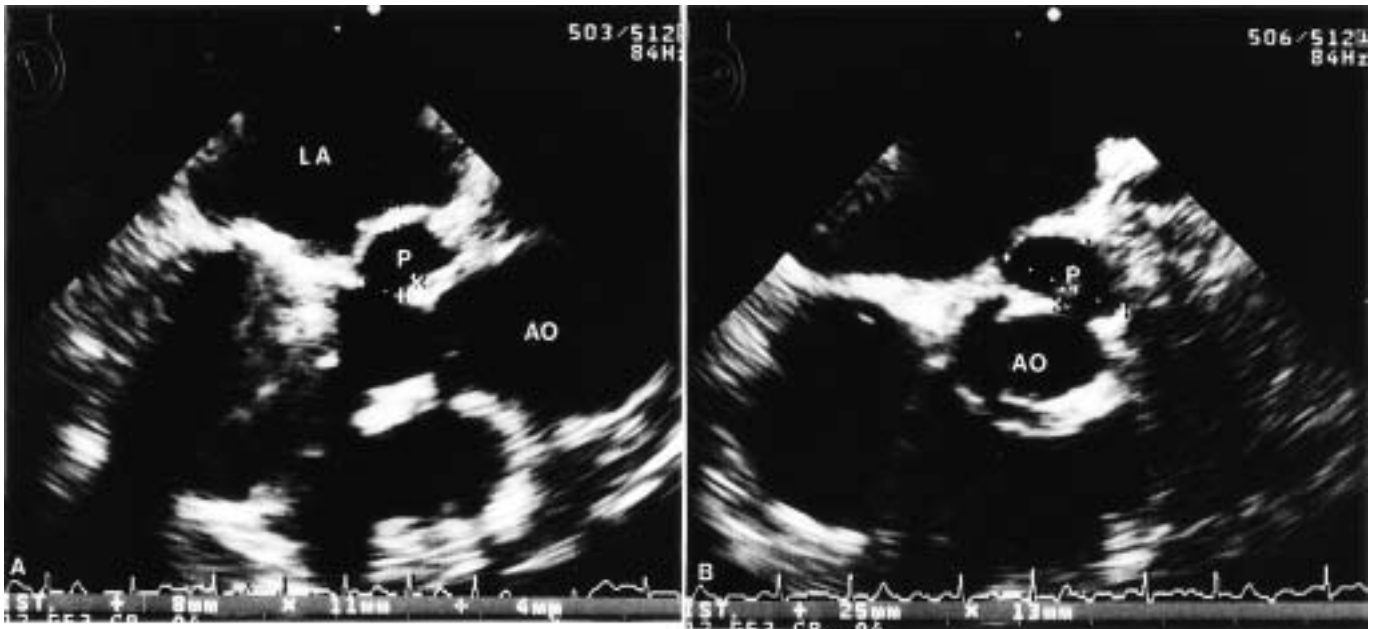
Transesophageal echocardiograms (A, long-axis; B, short-axis) showing an echo-free cavity in the mitral-aortic intervalvular fibrosa region just below the aortic annulus. Ao: Aorta; LA: Left atrium; P: Pseudoaneurysm.
